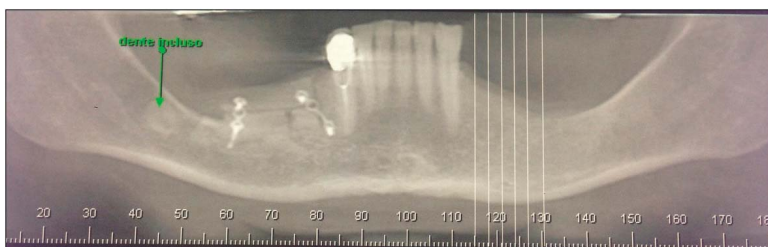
Panoramic image of the cone beam computed tomography showing the vertical bone gain obtained through sandwich osteotomy.
